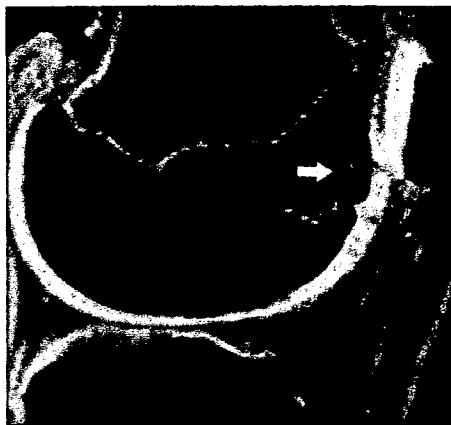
Sagittal MRI scan of patient 4 at 28 months post-operatively demonstrates 50% to 100% defect fill and large area of abnormal signals at the donor harvest site (white arrow).
